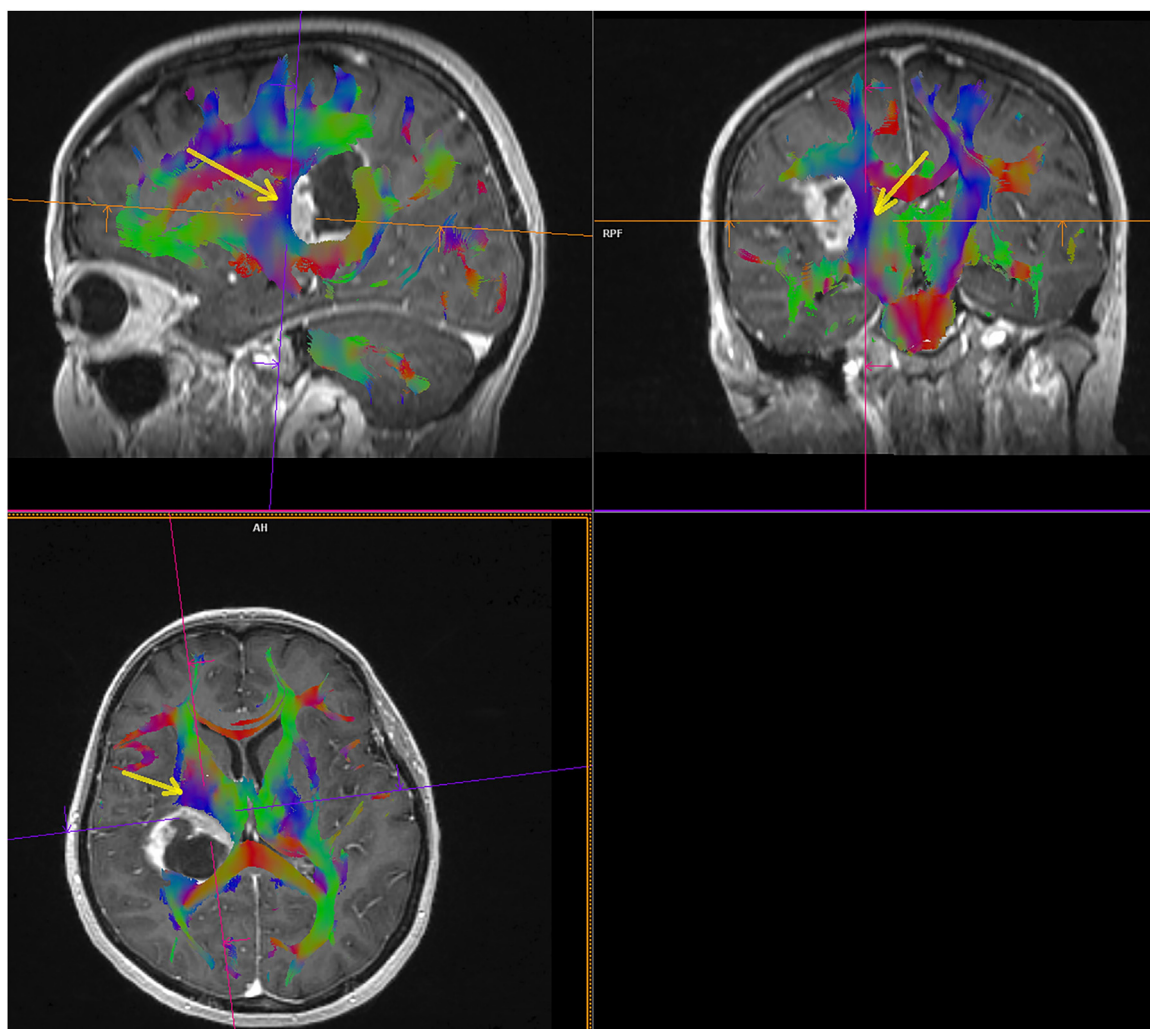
MRI of a patient with a right-sided posterior thalamic tumor. The internal capsule is located medially and anteriorly from the tumor. Interhemispheric parasplenial approach was adopted. As a result, the patient did not present with postoperative paresis or hemianopia.
